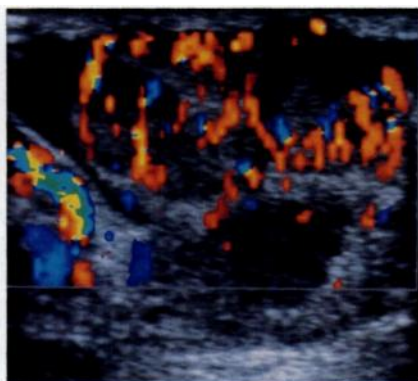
74-year-old man with painless bilateral testicular enlargement proved to be diffuse large-cell lymphoma. Longitudinal sonogram of testes shows rounded, nodular, hypoechoic foci with strikingly increased vascularity.
